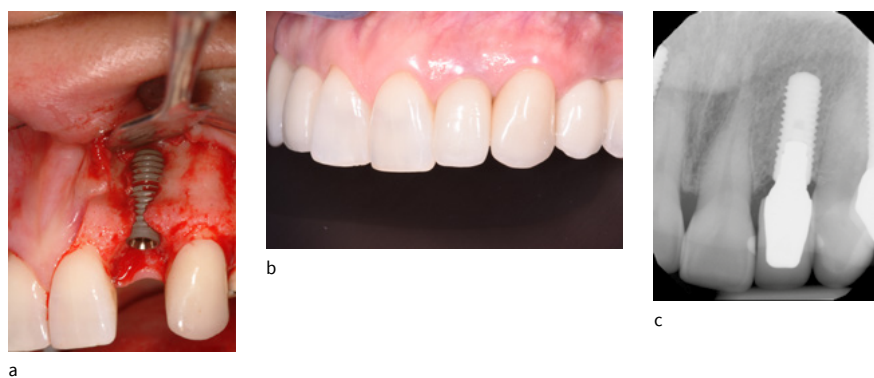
Cylindrical implant caused need for additional grafting. A similarly sized tapered implant was not available at the time of surgery. 10-year result shows that despite this macro-design-induced challenge, excellent esthetic results and tissue stability were achieved. a: surgical placement with significant apical protrusion of the cylindrical implant. b: 10-year clinical result showing stable tissue contours. c: 10-year radiograph showing stable proximal bone levels
